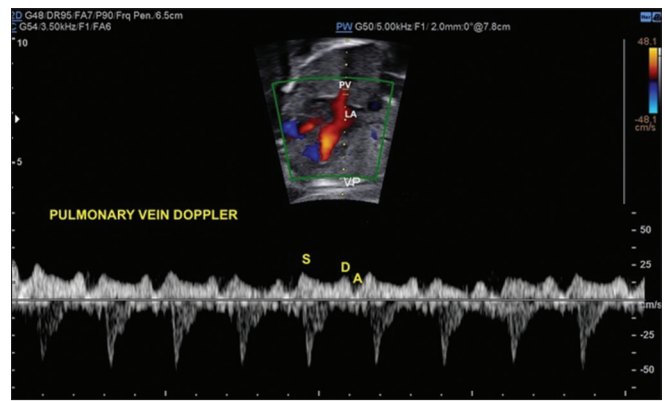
Pulmonary vein Doppler obtained at four-chamber view at the venoatrial junction, at the right superior pulmonary vein with the left atrium showing normal pattern flow (S, D, and A waves). PV: Pulmonary vein, LA: Left atrium, S: systolic wave, D: Diastolic wave, A: Presystolic velocity (during atrial contraction)
